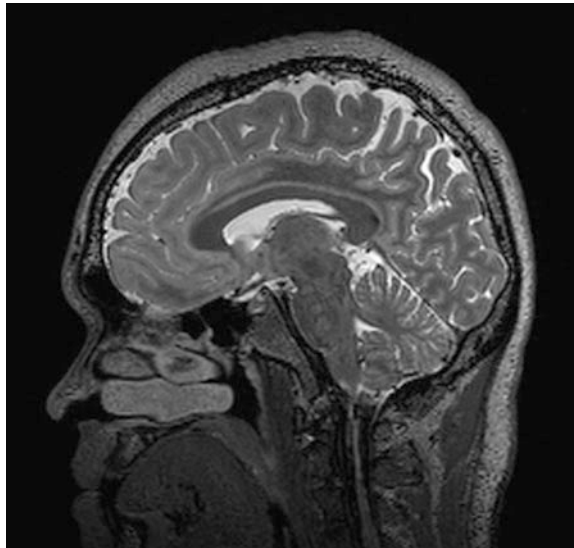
T2 weighted MR image acquired in the sagittal plane
